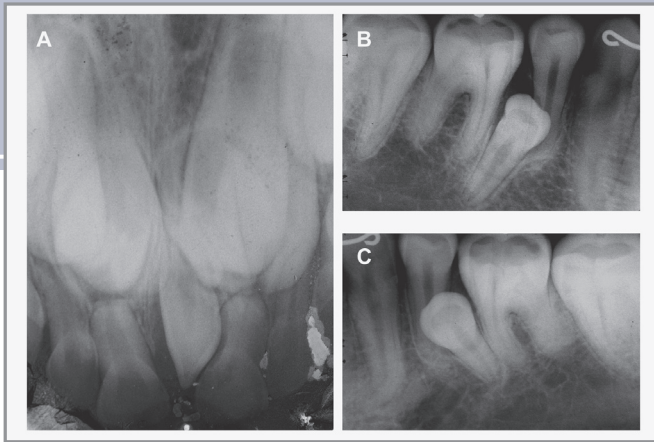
(A) Periapical radiograph revealing 3 bilateral supernumerary teeth (ST) in the maxillary central incisor region. (B and C) Fifteen years later, the patient developed 2 more bilateral ST in the mandibular premolar region.
